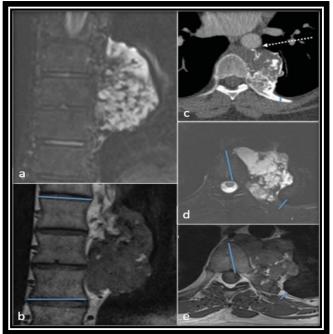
Chondrosarcoma. Coronal short tau inversion recovery (STIR) (A) T1(B), axial computed tomography (C), axial STIR (D) and T1 (E) showing resection margins (blue lines). Arrow showing the tumor is close to the aorta. (Weinstein-Boriani-Biagini 2–6, A).
